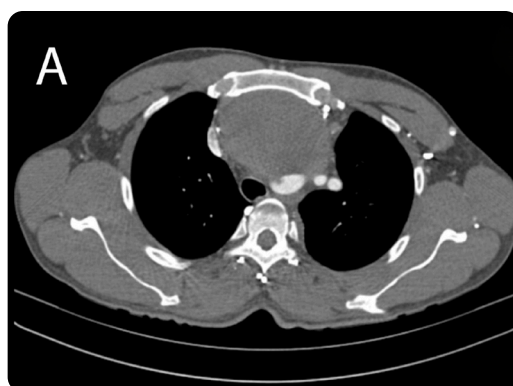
a). Axial angio-CT scan of the aorta showing a low density image due to thrombus in the anterior mediastinum, which displaces the trachea, the tracheoesophageal angle and the supra-aortic vessels laterally. b) Intramural thrombus surrounding the aortic lumen on its left lateral side. Descending aorta of usual appearance and diameter. c) Multiplanar reconstruction of aortic CT angiography in sagittal plane, showing the relationship of the aneurysm with adjacent structures and the emergence of the supra-aortic trunks. d) Multiplanar reconstruction of aortic CT angiography in coronal plane.
